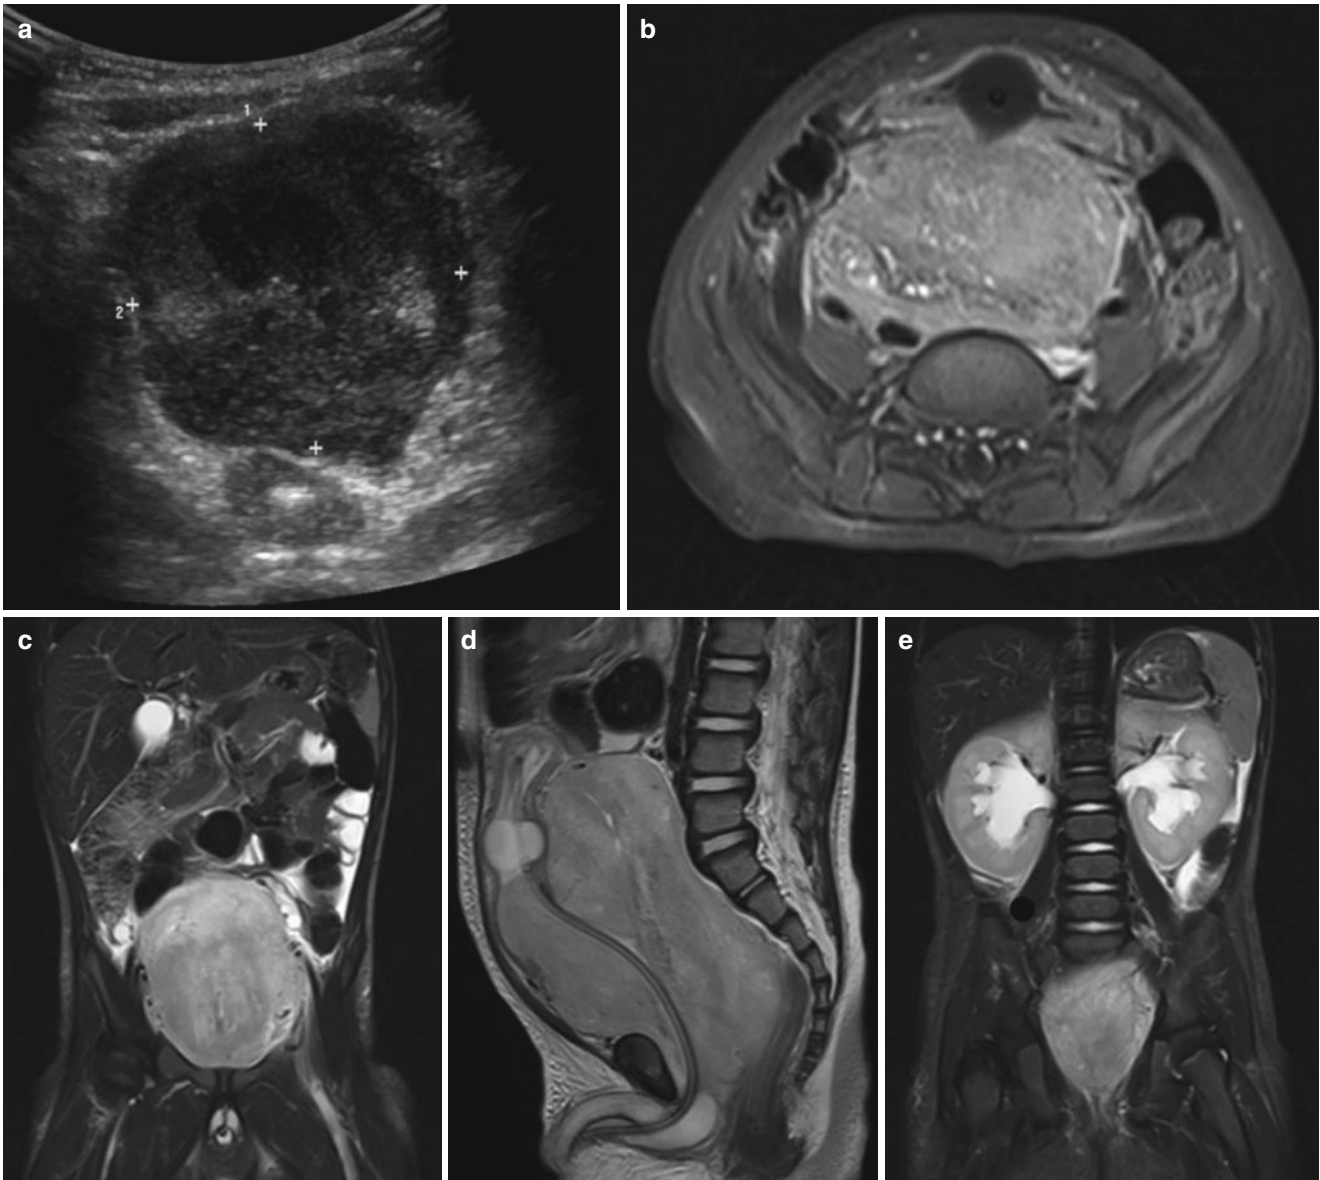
Prostatic rhabdomyosarcoma. Ultrasound (a) shows the deep pelvic mass with the rectum compressed posteriorly. Axial (b) and coronal (c) MRI sequences show the large mass completely filling the pelvis. On the sagittal view (d), the mass extends deep into the perineum, and is likely to arise from the prostate, and the urinary bladder
